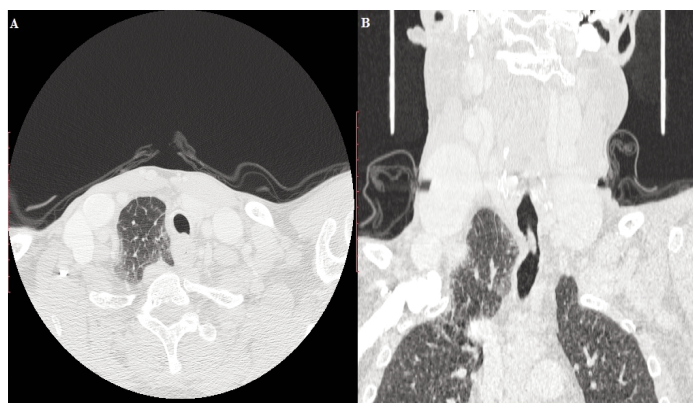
(A, B): Chest CT scan performed during a Valsalva manoeuvre shows herniated lung at the right apex. (A : axial view in parenchymal window, B: coronal view in parenchymal window)
